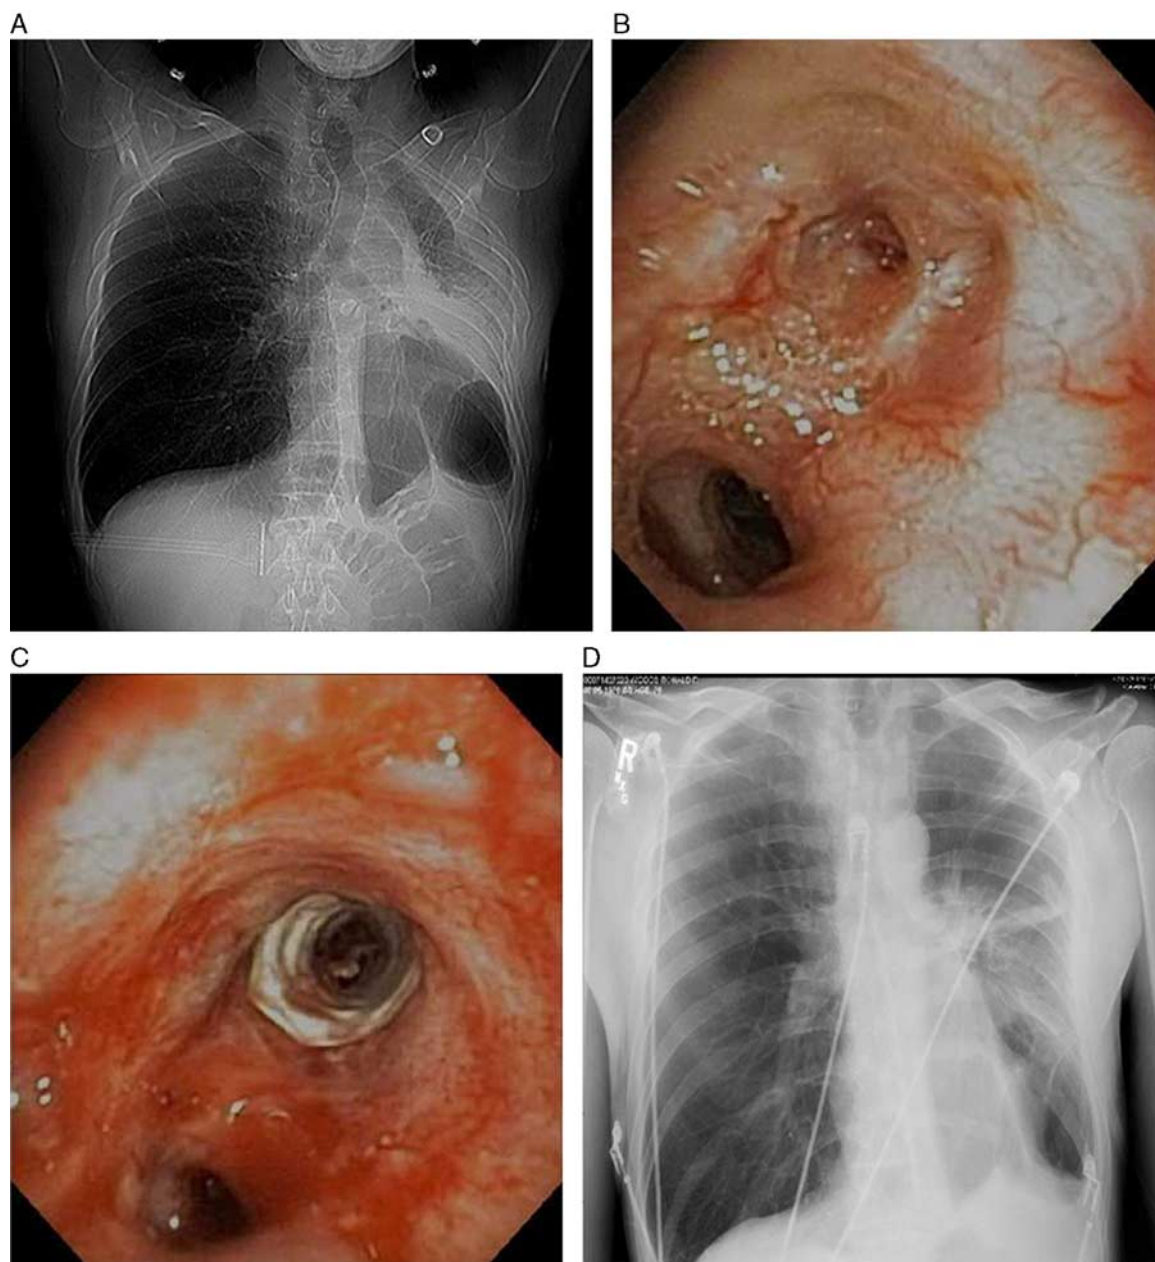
LUL bronchial stenosis secondary to radiotherapy. A, Chest radiograph before. B, Bronchoscopic image of LUL stenosis. C, Atrium iCast stent deployment in the LUL. D, Chest radiograph poststent deployment. LUL indicates left upper lobe.
